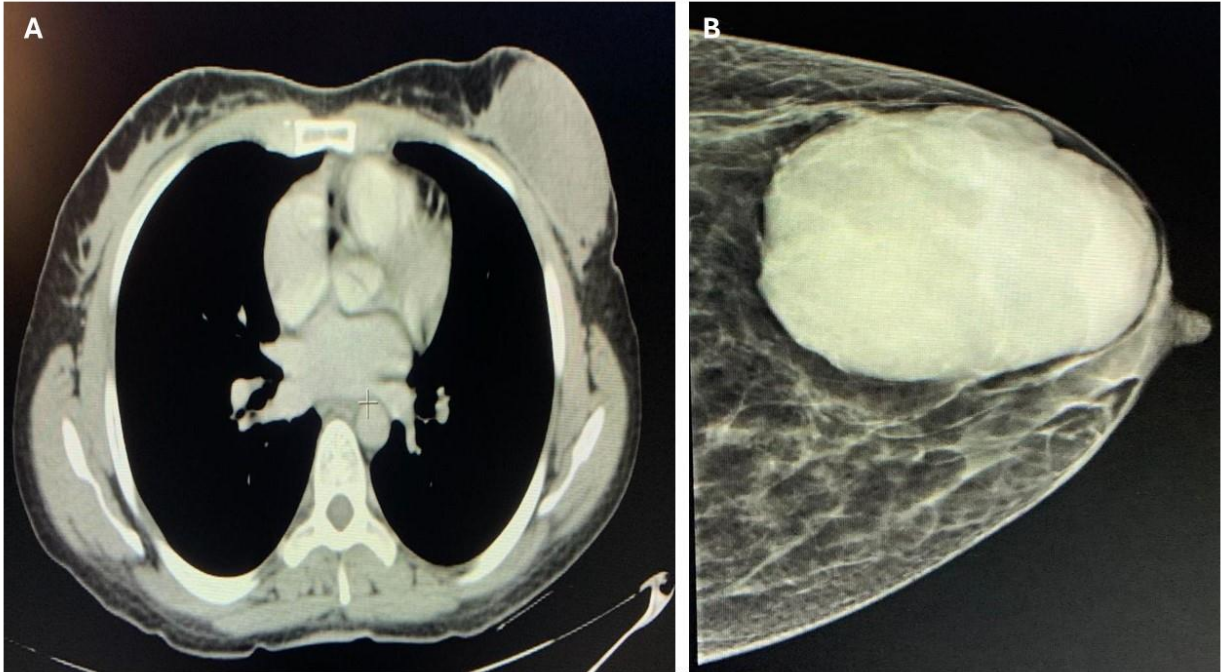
(A) Post-contrast CT study of the chest axial cut revealing a well-defined, faintly enhancing left breast soft tissue mass contacting underlying muscle, no intrathoracic extension. (B) Mammography mediolateral oblique view revealing a well-defined radioopaque opacity with a lobulated wall, no skin involvement, and no suspicious calcifications.
